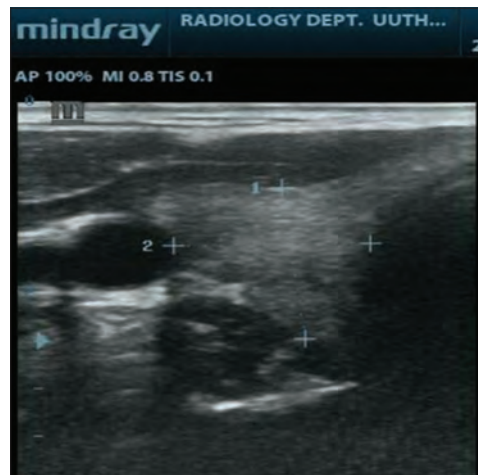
Transverse B-mode sonogram showing measurement of the right thyroid lobe's anteroposterior (thickness) and transverse (width) diameters
